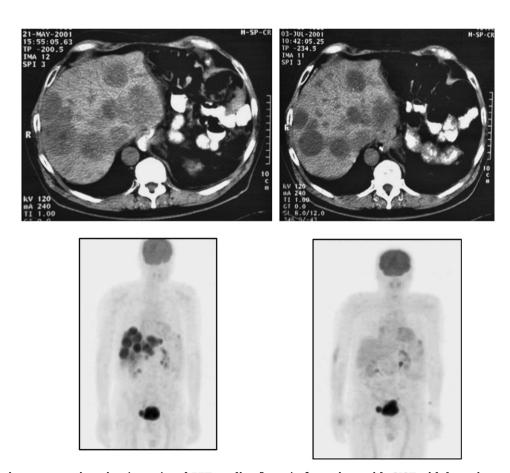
Magnetic resonance imaging (upper) and PET studies (lower) of a patient with GIST with hepatic metastases. The images on the left represent pretreatment baseline studies and those on the right were done after 4 weeks of imatinib therapy. The PET scans show nearly complete resolution of the metastases, a finding that is not substantiated in the MRI study. Courtesy of M. E. Scheulen, Innere Universitätsklinik (Tumorforschung), Essen, Germany.
